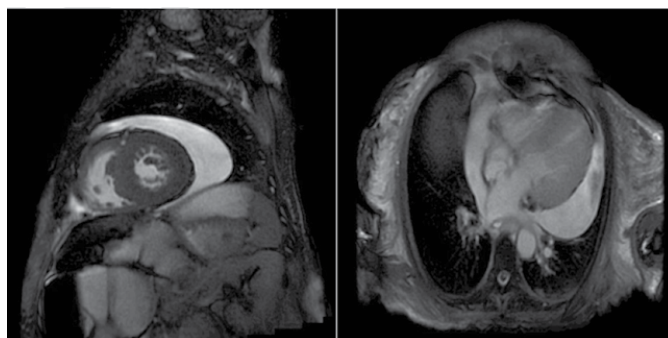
Cardiac MRI images showing the hypertrophied left ventricle with fibrosis. These images demonstrate features of both hypertrophic and restrictive cardiomyopathy.
